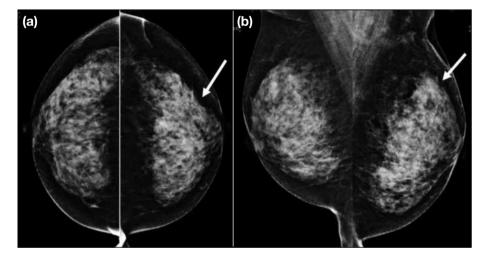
Subtle architectural distortion due to surgical scar mammography, better seen on on (a) craniocaudal view than (b) mediolateral view (arrows). This patient had undergone breast mass excision previously with pathology showing lupus mastitis. She subsequently had core biopsy of the area of architectural distortion due to new development of corresponding hypoechoic changes on ultrasonography, with pathology being negative for malignancy. This patient was followed up for >6 years without recurrence of lupus mastitis.
